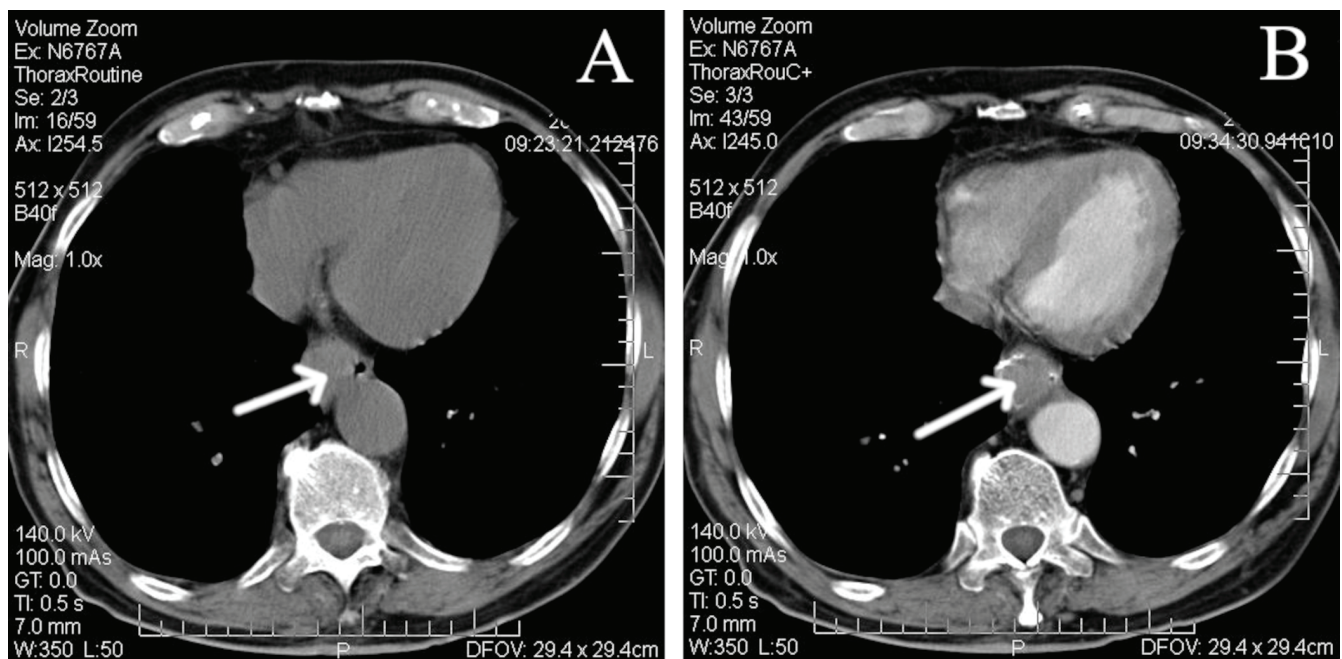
Case 4. Contrast-enhanced computed tomography (CECT): infiltrative lesion in the distal part of esophagus up to 35 mm in diameter (arrows), without radiological features of metastases
